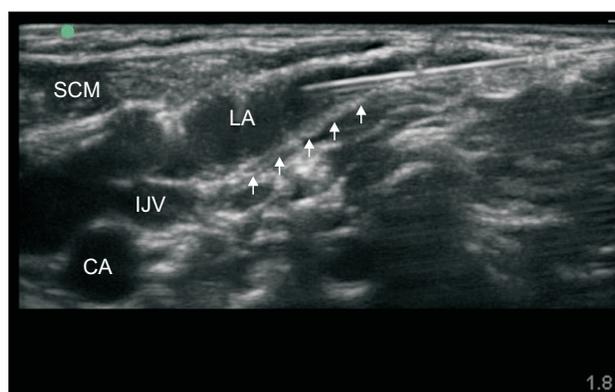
Ultrasound image of the posterior approach for an intermediate cervical plexus block at C4–5 level in a 3-year-old torticollis patient undergoing unipolar sternocleidomastoid (SCM) release with myectomy. Hydrodissection of the posterior cervical space between the SCM muscle and prevertebral fascia by local anesthetic is seen, and local anesthetic spreads to the area near the carotid sheath. CA: carotid artery, IJV: internal jugular vein, LA: local anesthetic. White arrow points: prevertebral fascia.
